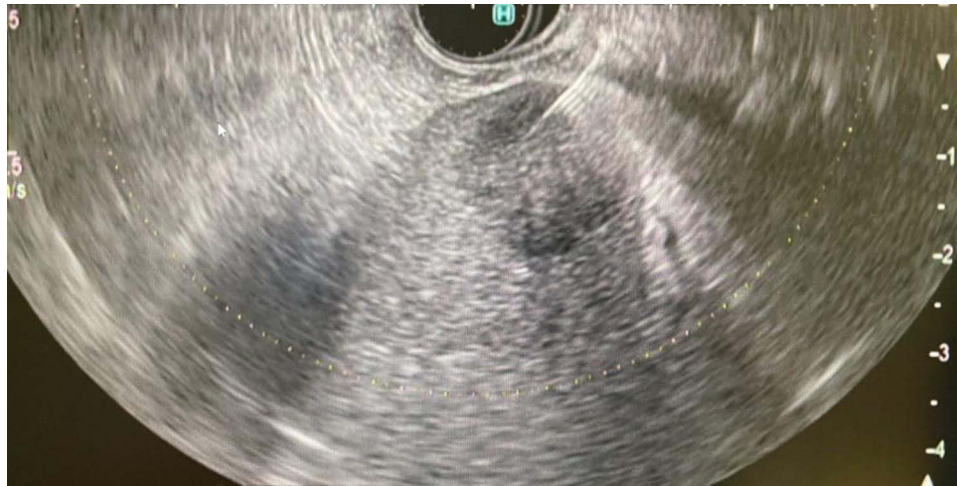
Endoscopic ultrasound-guided fine-needle aspiration/biopsy puncture of a splenic focal lesion.
